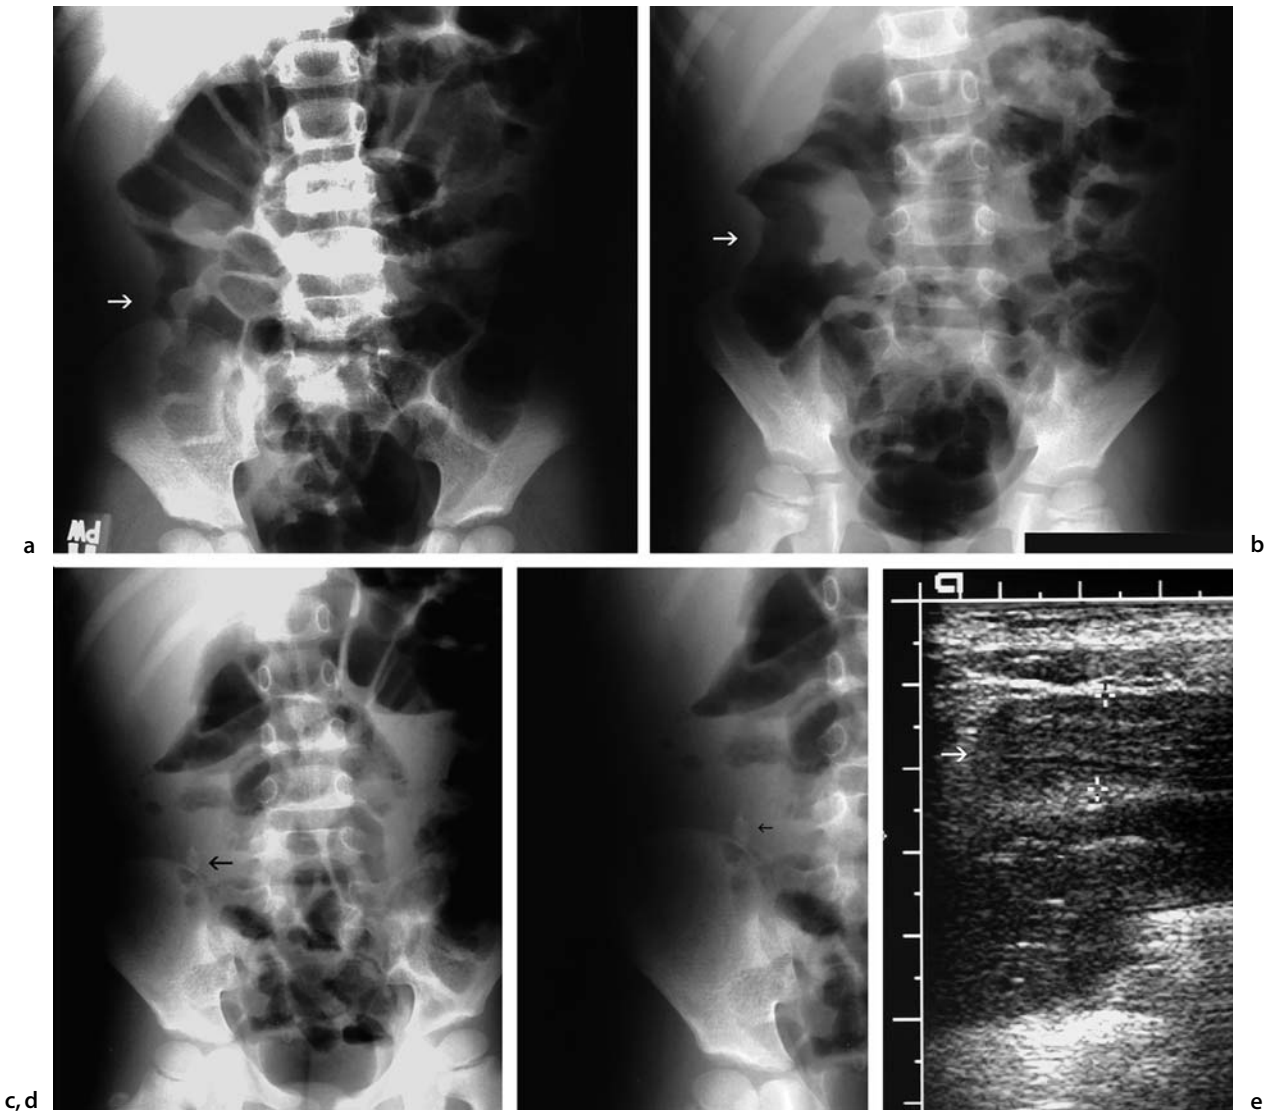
Plain film and ultrasound of appendicitis
